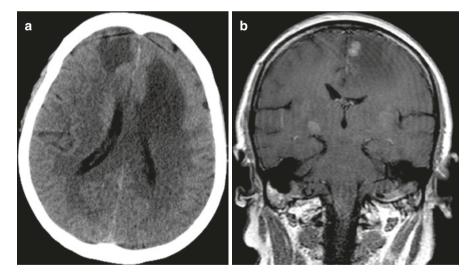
A 47-year-old male with biopsy-proven adenocarcinoma of the rectum. (a) Axial noncontrast CT image of the brain demonstrates hypodensities in bilateral frontal lobes corresponding to substantial edema. (b) Post-contrast T1W coronal MR image demonstrates multiple metastatic masses with surrounding edema and nodular enhancement. Although the patterns are non-specific, the multiplicity of lesions together with subcortical locations and substantial perilesional edema is convenient with multiple brain metastases
